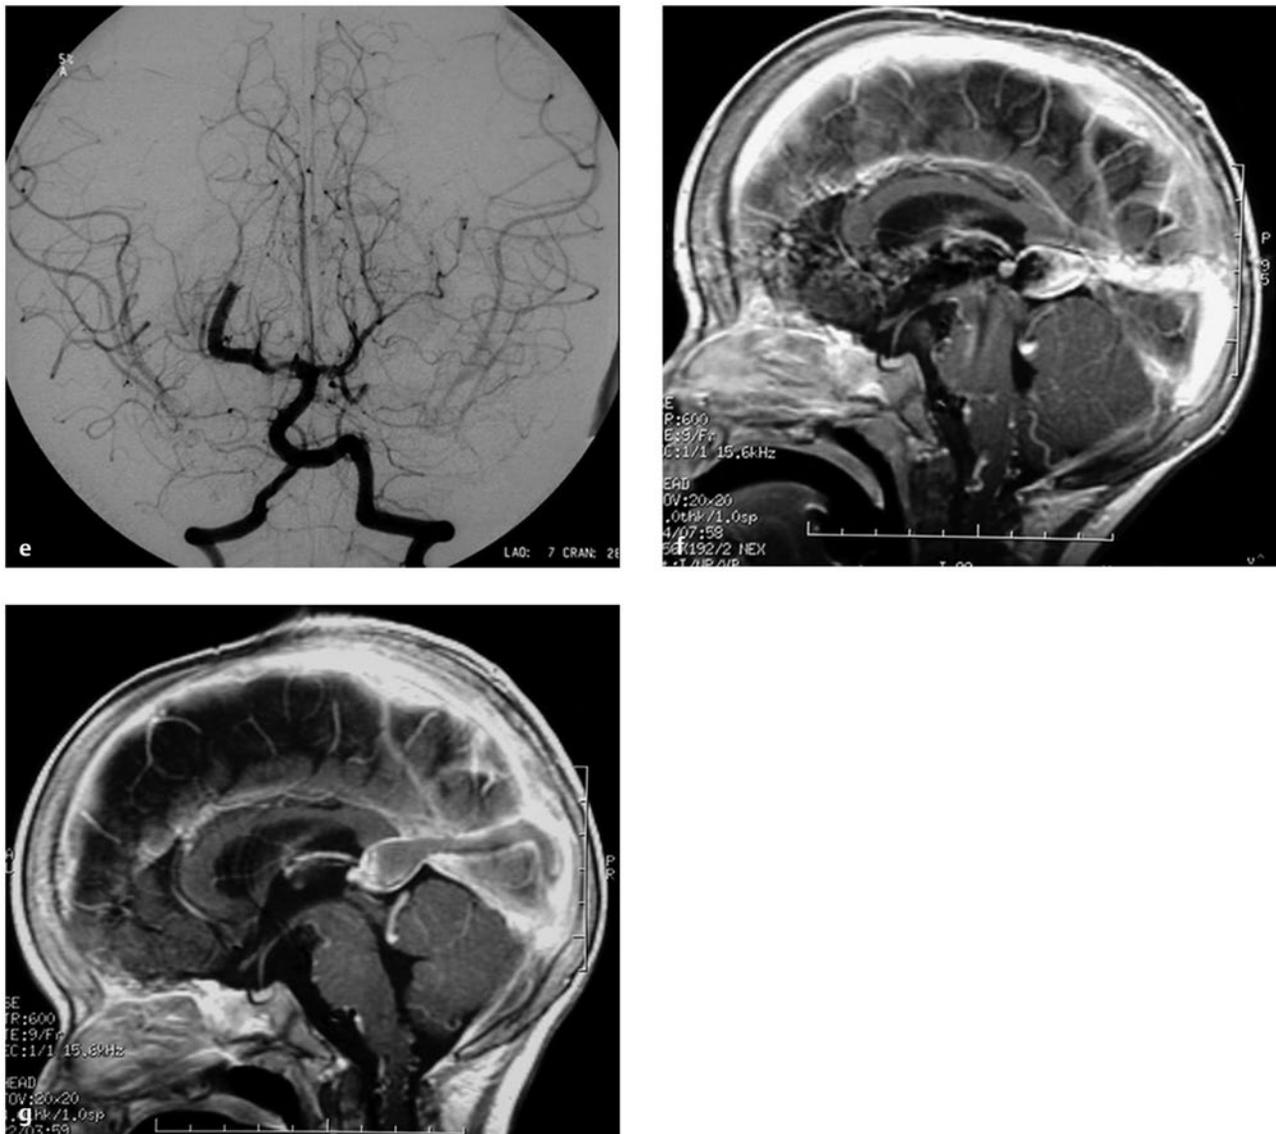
(continued) (e) The patient underwent endovascular embolization with *N*-butyl-cyanoacrylate (NBCA), resulting in complete occlusion of the single-hole fistula. T1-weighted sagittal MR imaging with contrast (f) before and (g) after the embolization showing decreased congestion of the brain and thrombosis of the vein of Galen and embryonic falicine sinus. Note the increased cerebrospinal fluid space and decreased size of the veins in the posterior fossa after embolization. The patient was discharged neurologically intact without seizures.
